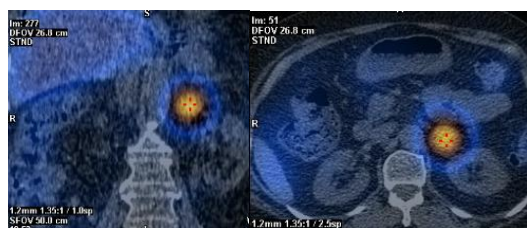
MIBG scintigraphy: Left adrenal pheochromocytoma
